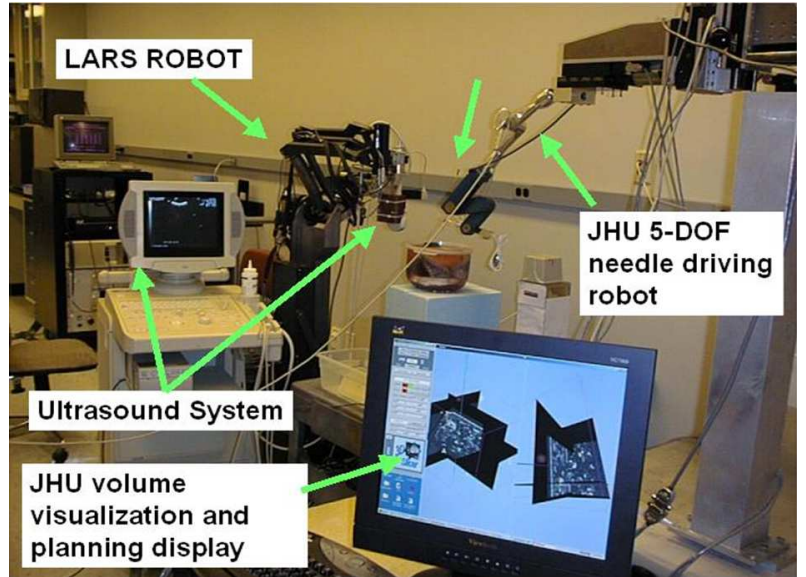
Current Hardware: Ultrasound Robot
